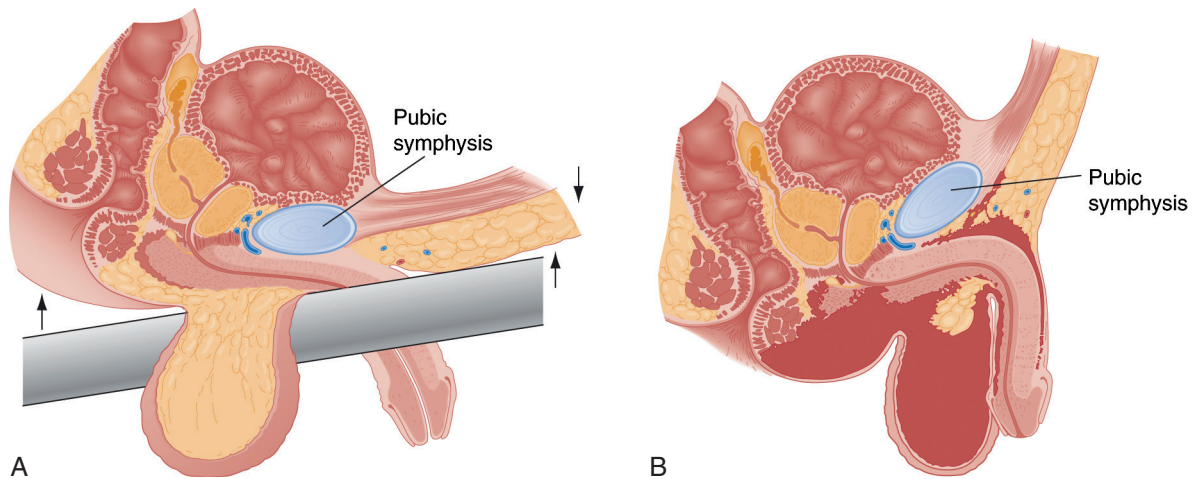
Injury to the bulbous urethra due to straddle mechanism. A, Mechanism: Usually a perineal blow or fall astride an object, crushing the urethra against inferior edge of pubic symphysis. B, Extravasation of blood and urine enclosed within Colles' fascia. (From McAninch JW: Injuries to the genitourinary tract. In Tanagho EA, McAninch JW, editors: *Smith's general urology*, ed 14, Norwalk, CT, 1995, Appleton & Lange.)
